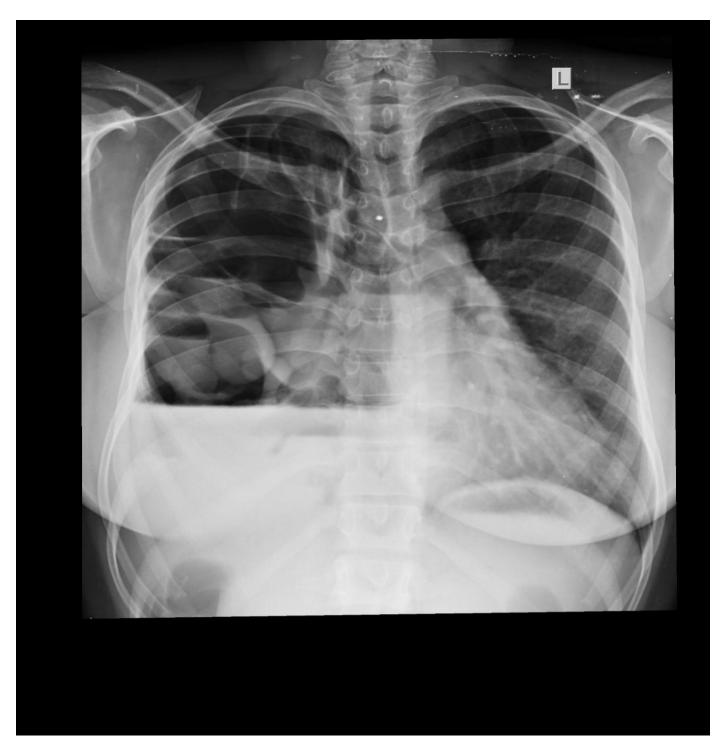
A chest X-ray radiograph of the patient
